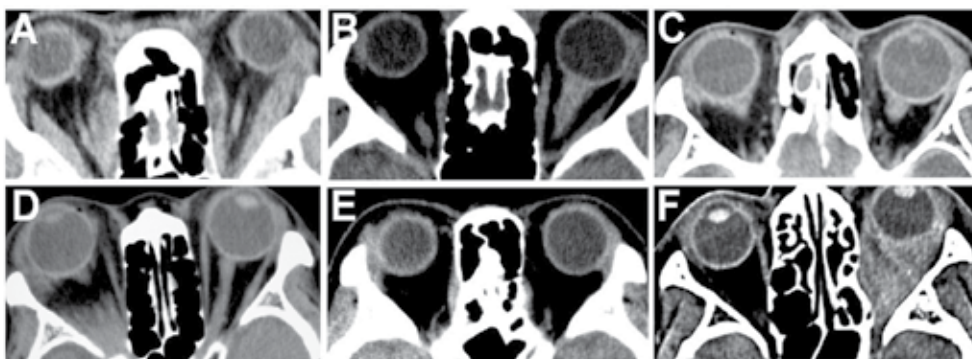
CT images of each type of idiopathic orbital inflammation. A: orbital myositis, B: perioptic type, C: periocular type, D: apical type, E: lacrimal type, F: diffuse type
